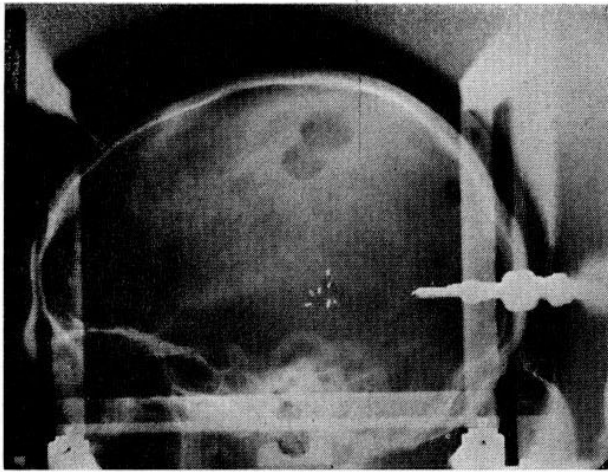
Case 2. Operative radiograph of gold seeds in position.
